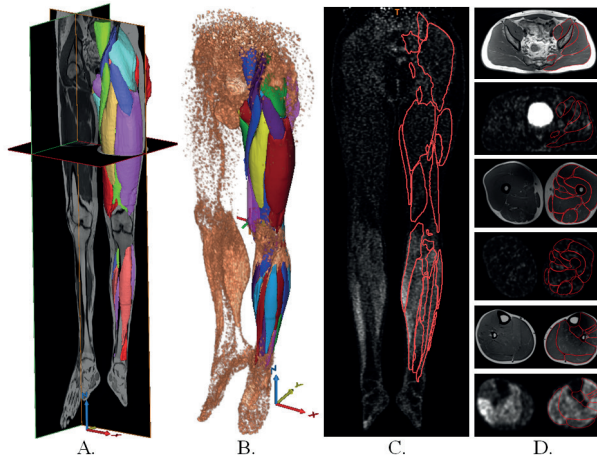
A: MRI scan with three-dimensional muscle ROI. B: PET scan with three-dimensional muscle ROI. C: Frontal view of a PET scan with muscle ROI. D: MRI and PET scan slices of the hip, thigh, and lower leg regions with muscle ROI as used in the slice-based analysis.
